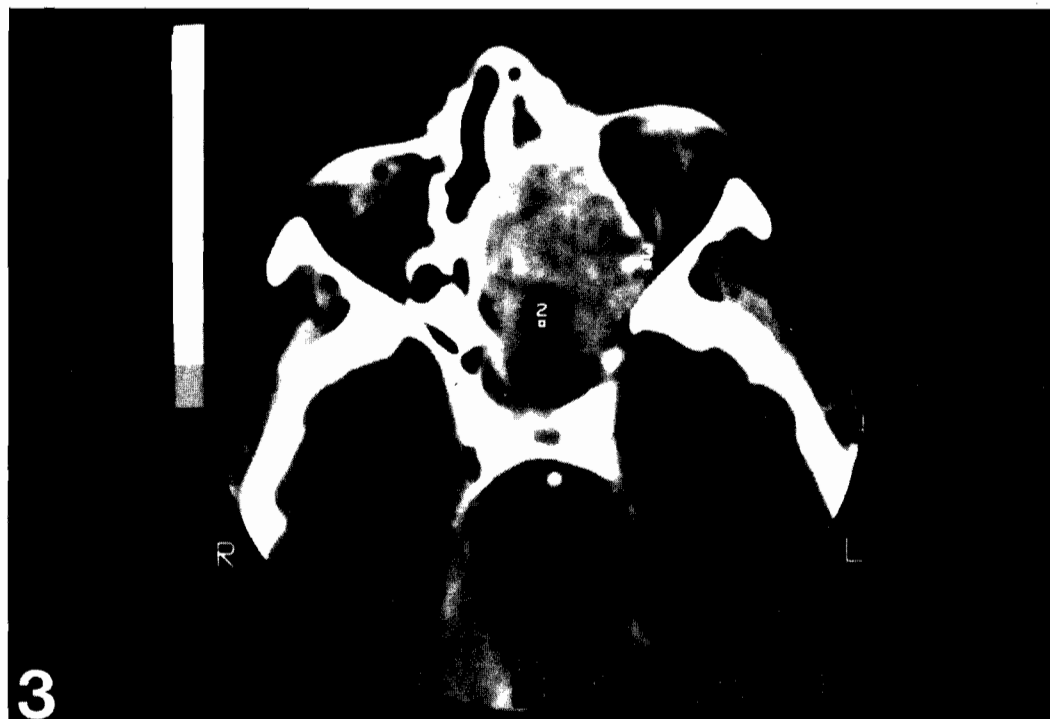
R.R.: Preoperative CT scan showing a large mass involving the right maxillary antrum, ethmoidal labyrinth and nasal fossae.
